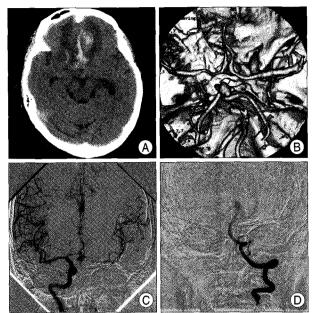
A: Computed tomography taken 9 years after therapeutic carotid occlusion showing subarachnoid blood in the interhemispheric fissure and hematoma in the septum pellucidum. B: Computed tomographic angiogram revealing a de novo aneurysm at the anterior communicating artery and remarkable growth of the saccular aneurysm of the basilar bifurcation. C: Right carotid angiogram revealing an anterior communicatin artery aneurysm. D: Left vertebral angiogram showing a remarkable enlargement of basilar apex aneurysm.
